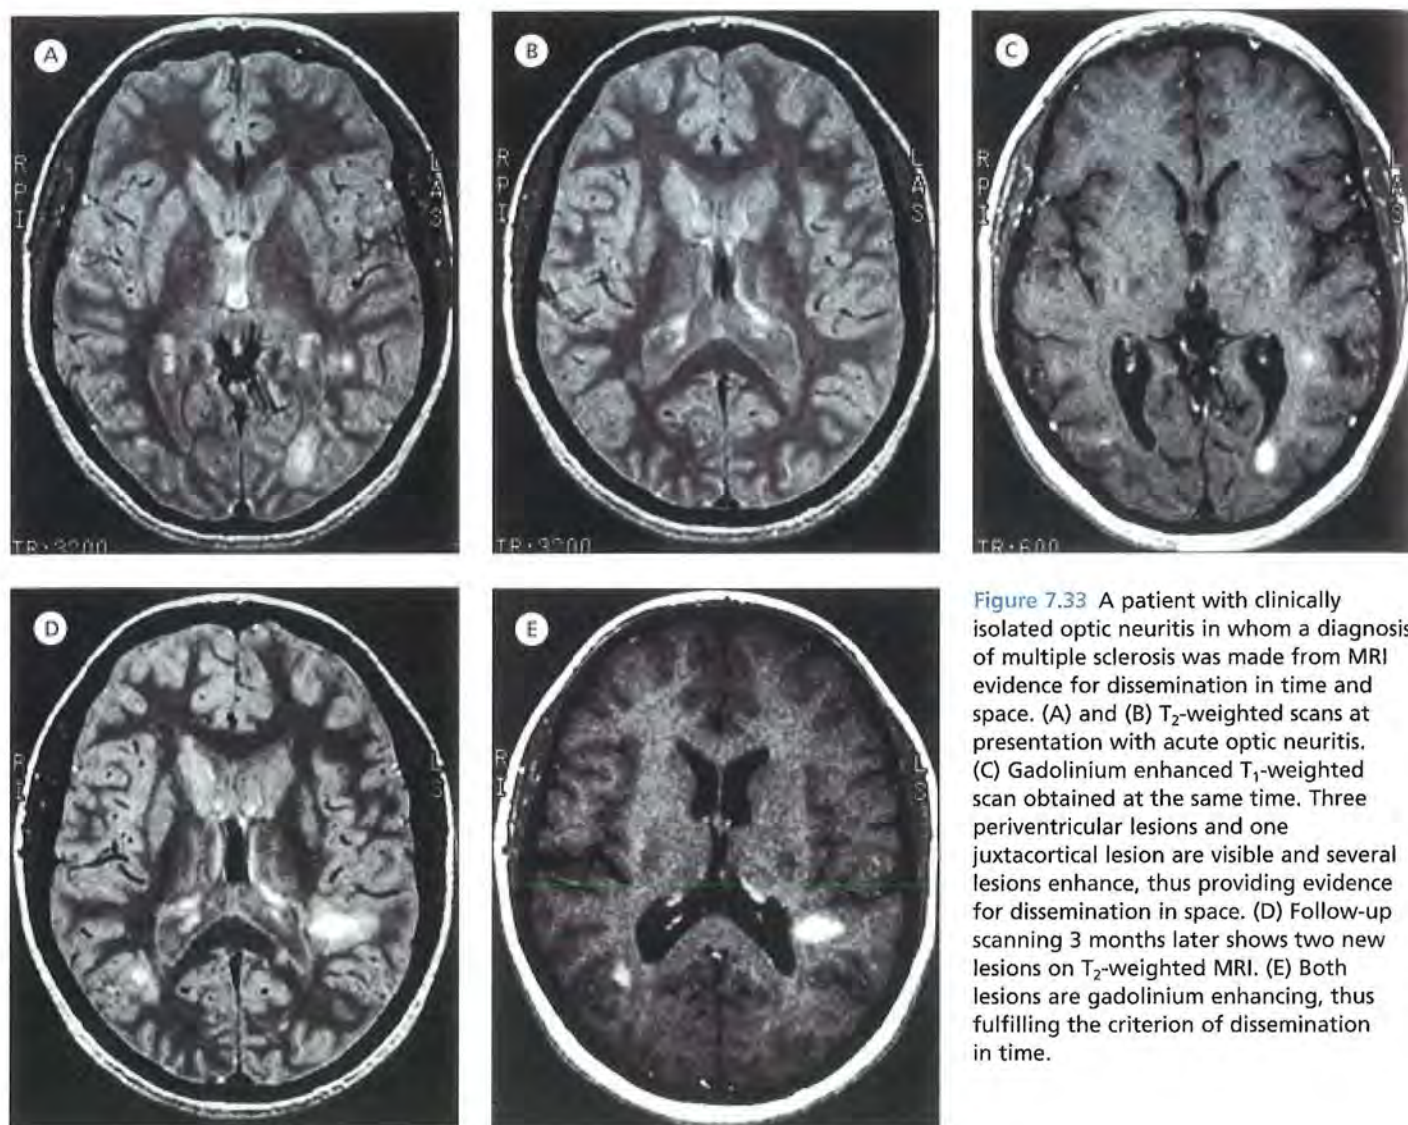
A patient with clinically isolated optic neuritis in whom a diagnosis of multiple sclerosis was made from MRI evidence for dissemination in time and space. (A) and (B) T₂-weighted scans at presentation with acute optic neuritis. (C) Gadolinium enhanced T₁-weighted scan obtained at the same time. Three periventricular lesions and one juxtacortical lesion are visible and several lesions enhance, thus providing evidence for dissemination in space. (D) Follow-up scanning 3 months later shows two new lesions on T₂-weighted MRI. (E) Both lesions are gadolinium enhancing, thus fulfilling the criterion of dissemination in time.
